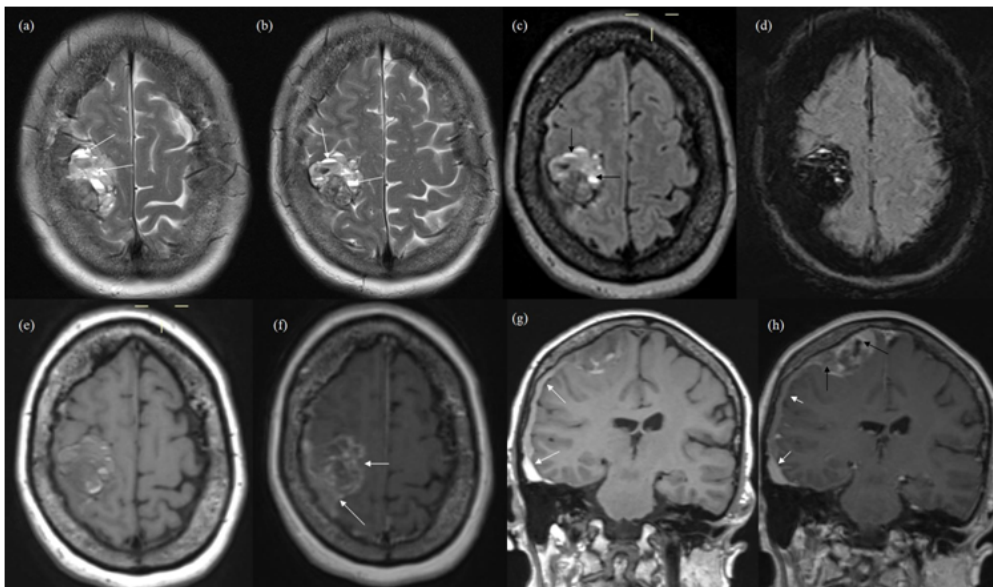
MRI scan. T2-weighted images (a,b) show the mass with several small fluid-fluid levels suggesting areas of haemorrhage (white arrows). FLAIR images (c) also show fluid-fluid levels (black arrows). SWI (susceptibility weighted images) (d) show blooming artefact further suggesting haemorrhage. T1-weighted axial images (e-non contrast and f-post contrast), show areas of enhancement within tumour in (f) as white arrows. T1-weighted coronal images (g-non contrast and h-post contrast) show subdural haemorrhage in (g,h) as white arrows. Enhancement within the tumour is again noted in post contrast images (h) as black arrows.
